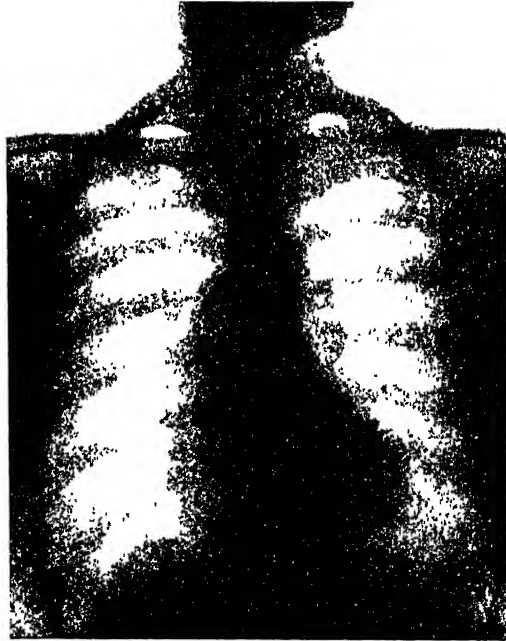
Radiograph of Fallot's tetralogy, showing *cœur en sabot*, concavity in region of pulmonary artery, and aorta projecting to right
